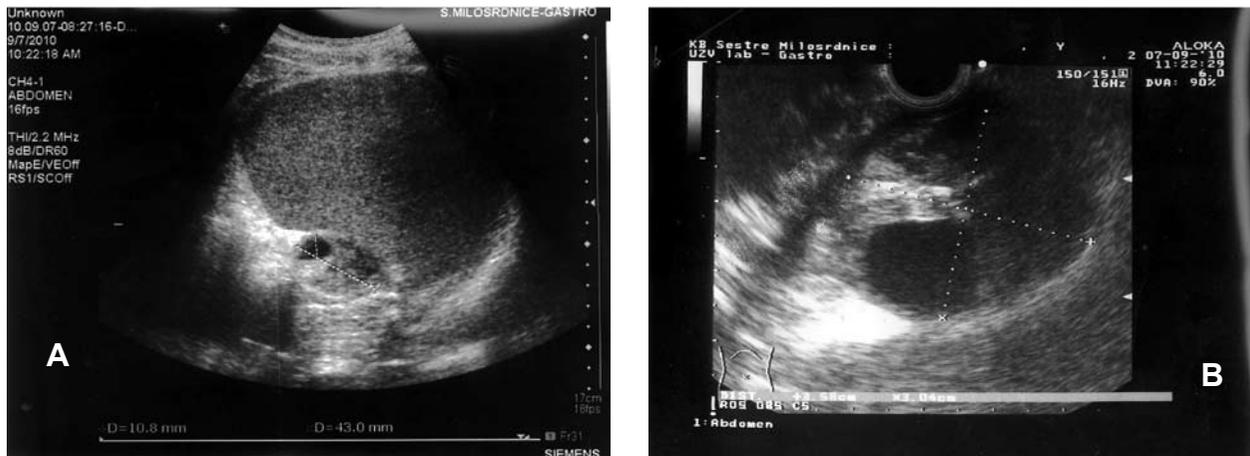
(A) Abdominal ultrasound; (B) endoscopic ultrasound, both showing a cystic lesion of 4x4.5 cm in size, in the projection of the spleen.
